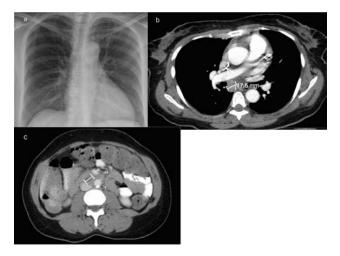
a: X-ray of the thorax. b: subcarinal lymphadenopathy (between two parallel lines). 1c: portacaval lymphadenopathy (between two parallel lines)
